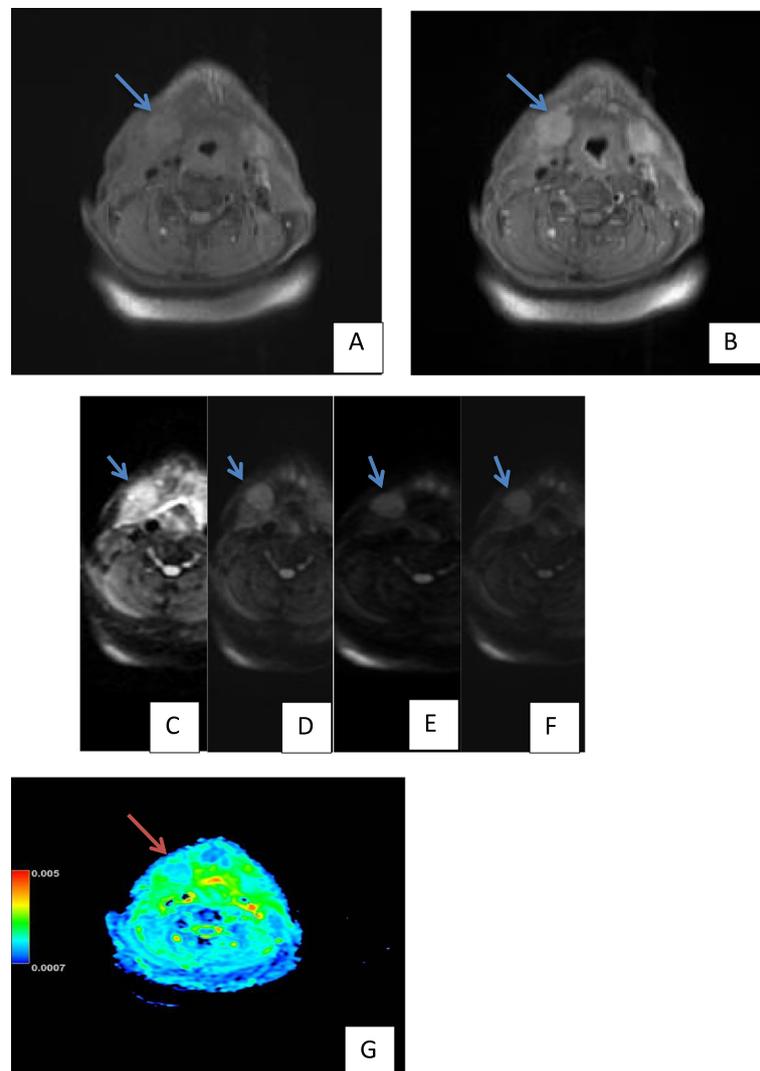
Thirty-three-year-old female patient with right submandibular lymphadenitis. a Axial T1. b Axial T1 + C. c–f Axial diffusion-weighted imaging with b values: 50, 400, 800, and 1000 respectively. g ADC map axial images showed mild enlarged right submandibular gland with no focal lesion; it displays homogeneous isointense signal intensity in T1, homogenous enhancement after IV contrast. The gland elicits high signal intensity in DWI, in both low and high b values, with corresponding intermediate signal intensity in ADC map (partially restricted diffusion), ADC value = 1.67×10^{-3} s/mm² (intermediate)
